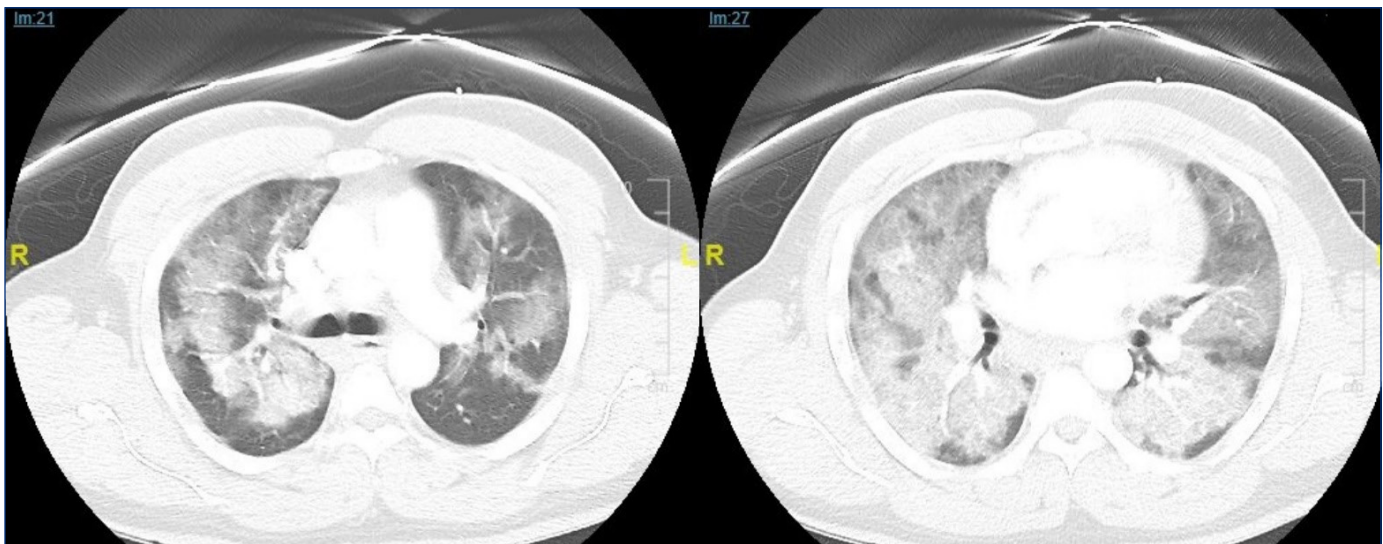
Chest computed tomography: Axial slices on lung windows demonstrating multifocal airspace disease with ground glass opacities.
